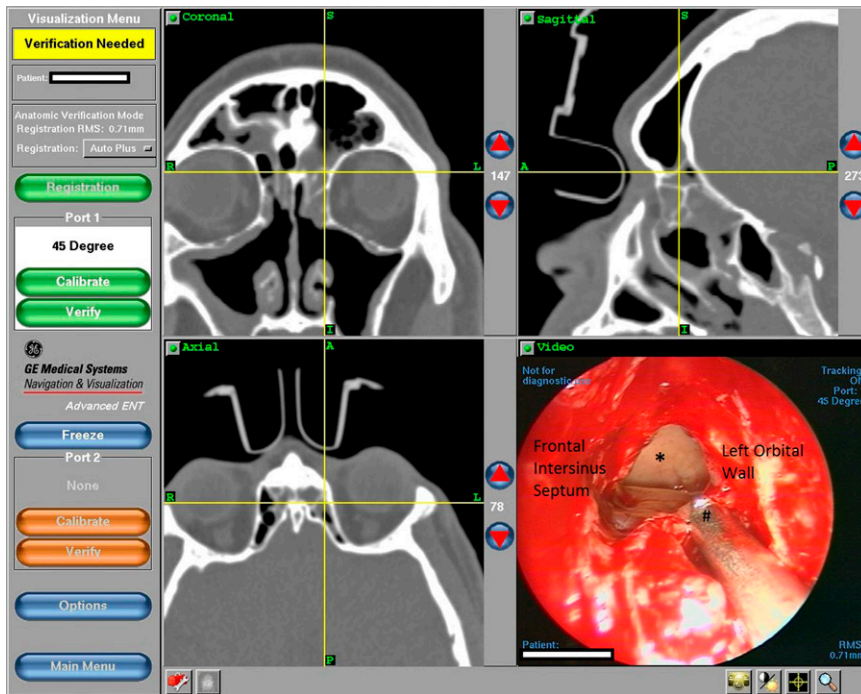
Intraoperative view with computed tomography (CT) image guidance of the left frontal sinus. *Indicates roof of left frontal sinus; #indicates tip of image guidance probe, which corresponds to cross-hairs on triplanar CT images.
